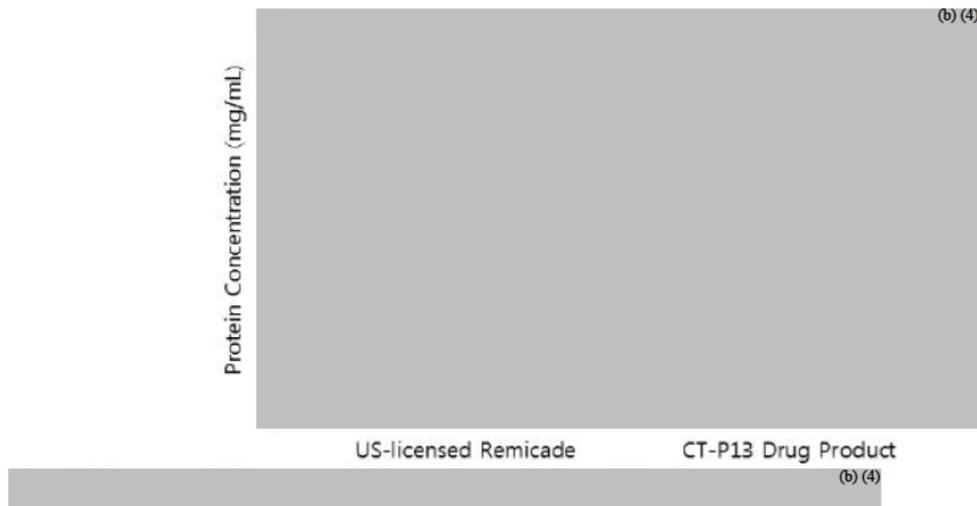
Comparison of Mean and Standard Deviation of Protein Concentration of CT-P13 and US-licensed Remicade[®] Batches
